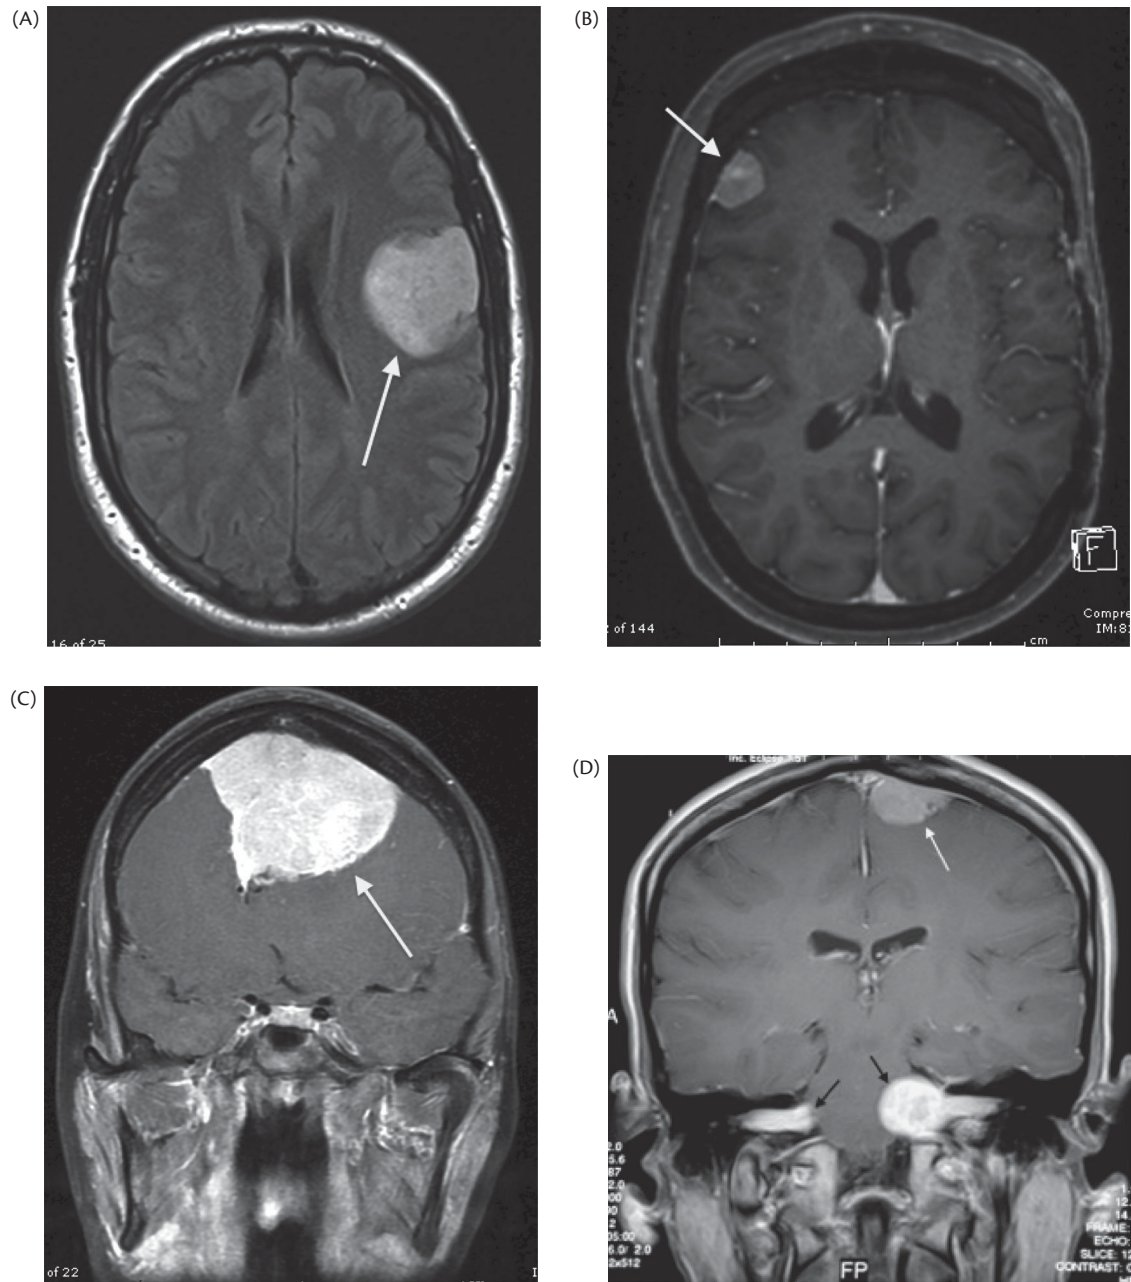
(A) Axial fluid-attenuated inversion recovery (FLAIR) brain MRI showing a left parietal low grade glioma. This tumour was diagnosed during pregnancy when the patient suffered sensory seizures. In retrospect she had suffered similar episode during a previous pregnancy that she had ignored. (B) Axial T1-weighted contrast-enhanced brain MRI showing a small right frontal meningioma (arrow). Small benign tumours can be observed during pregnancy with a low risk of significant enlargement. This tumour did not grow during pregnancy and the patient had a normal vaginal delivery. (C) Coronal T1-weighted contrast-enhanced brain MRI showing a large frontal falcine meningioma with significant mass effect. This tumour was not diagnosed during pregnancy and the patient had a normal vaginal delivery before suffering seizures in the postpartum period. (D) Coronal T1-weighted contrast-enhanced brain MRI showing typical lesions of neurofibromatosis-2 including bilateral acoustic neuromas (black arrows) with brainstem compression on the left, and a small convexity meningioma (white arrows). Decisions regarding pregnancy and delivery in the patients with an autosomal dominant inherited disorder and multiple intracranial and spinal lesions of varying size and severity are complex and should be made in a multidisciplinary setting.
